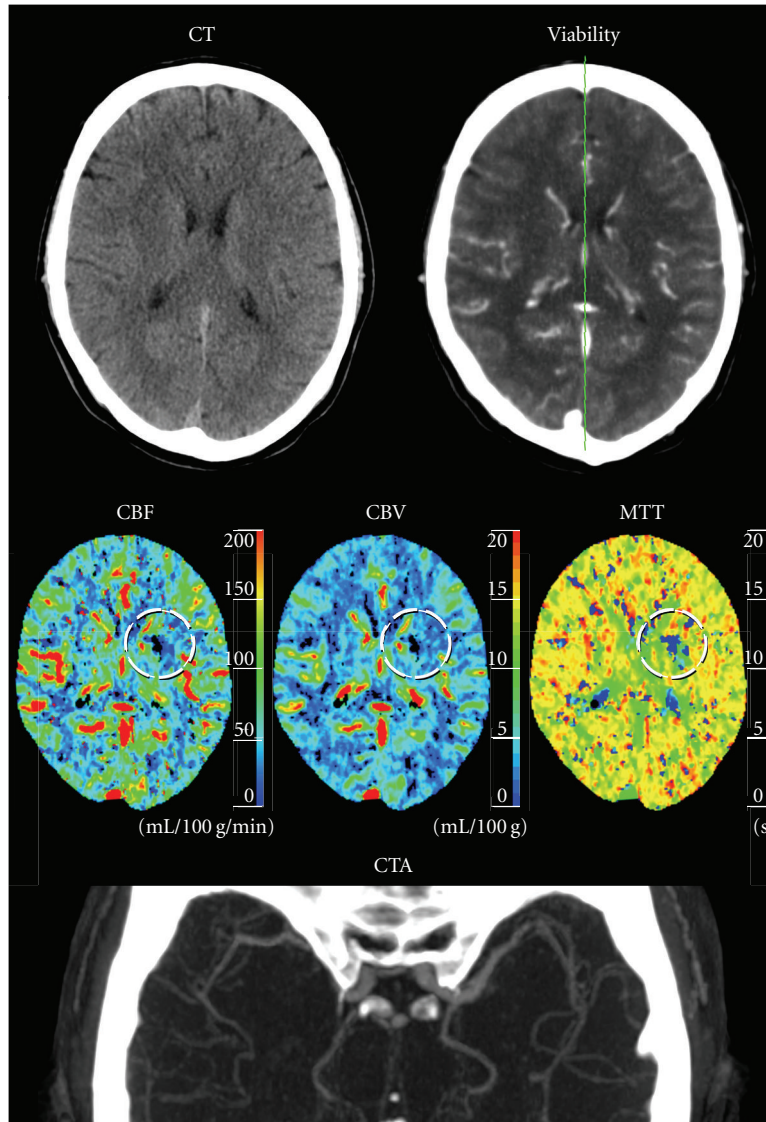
Case 3: 49-year-old male with right sided stroke symptoms and a normal NECT. The CTP source images show a small perfusion deficit in the left corona radiata with a marked decrease of both CBF and CBV (circle) that was initially missed by both the radiologist and the automated viability map software. CTA was normal.
